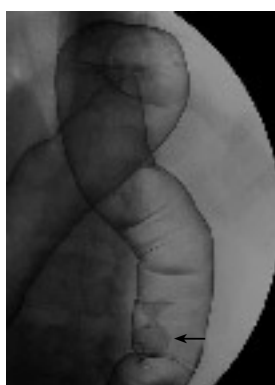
Double contrast radiograph of descending colon showing an about 20 mm peduncular polyp.
